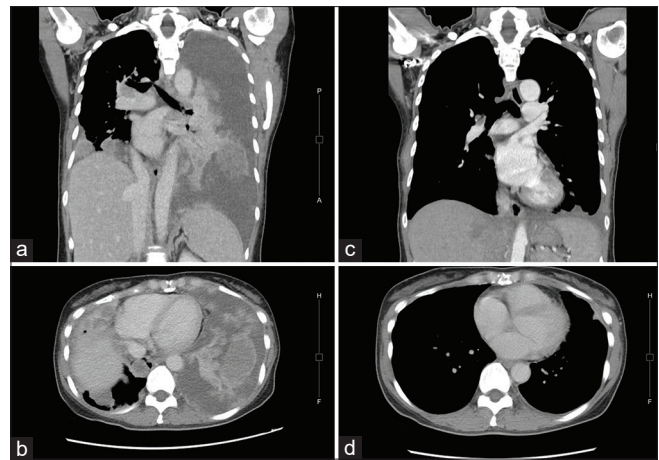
(a and b) Computed tomography (CT) scan before treatment in March 2022. (c and d) CT scan after 1 month of alectinib therapy in April 2022. The pleural tumor size significantly decreased
